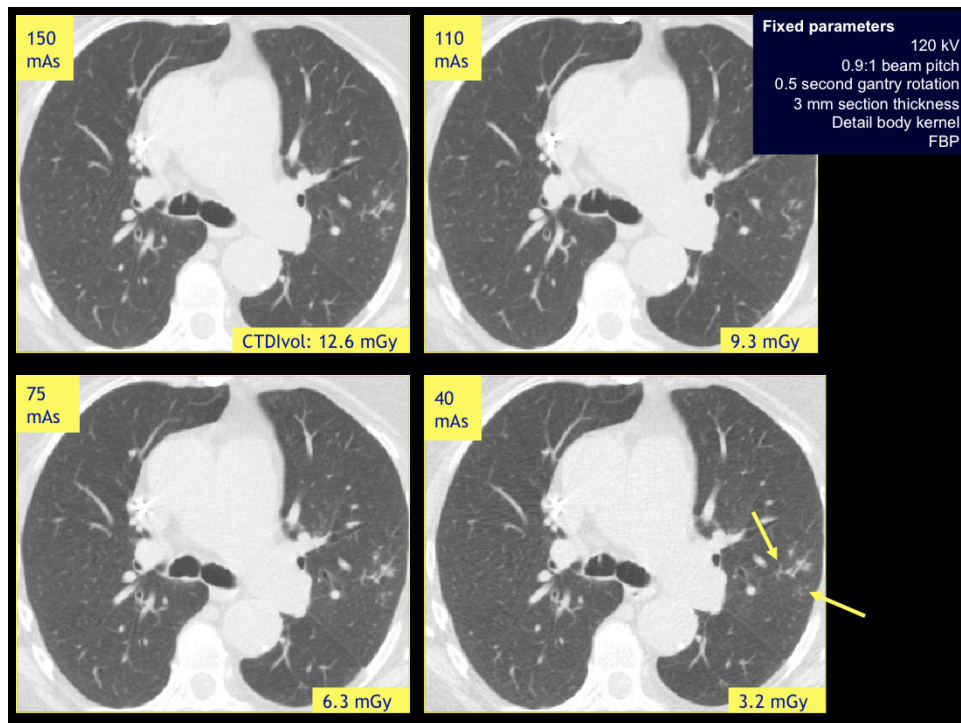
Chest CT acquired at various tube currents with a limited scan length of 10 cm to limit the total radiation exposure to the patient. Increased image noise noted in mediastinum is barely apparent in the lungs due to high background contrast between air and soft tissue density lung lesions and vessels. Note that four fold reduction in dose from 150 mAs to 40 mAs (3.2 mGy), has hardly any affect on visibility of small structures, left major fissure and clustered nodular opacity (arrow) in the left upper lobe.
